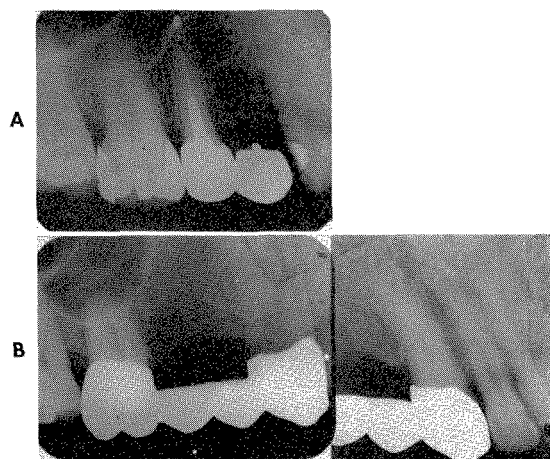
A, Roentgenograms taken in 1935 and in 1947. The second bicuspid was removed in 1946, and a fixed partial denture was constructed to replace both bicuspids, B. (Figs. 384 to 386 are of the same case.)
